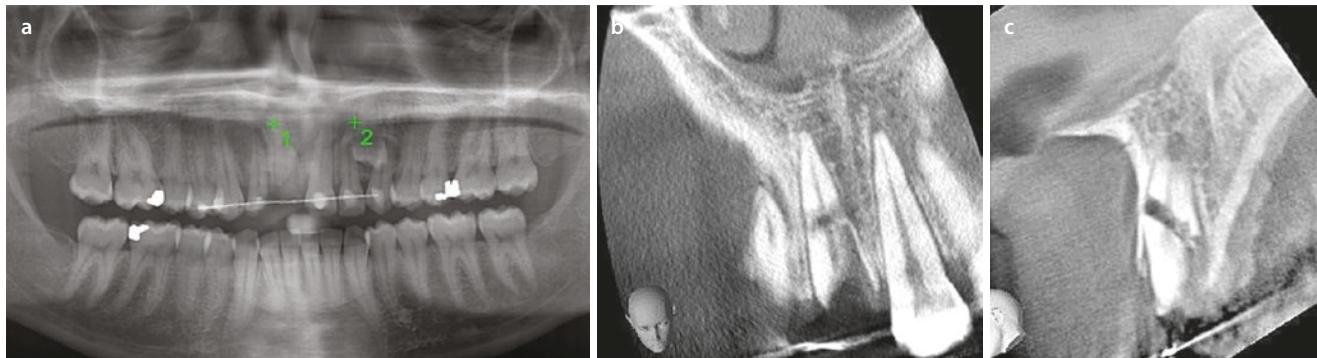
a Conventional dental radiography provides images in two dimensions which can make diagnosis difficult. This soccer player was kicked in the mouth during a game. It is difficult to determine the precise injury. b CBCT allows us a three-dimensional look at the same
